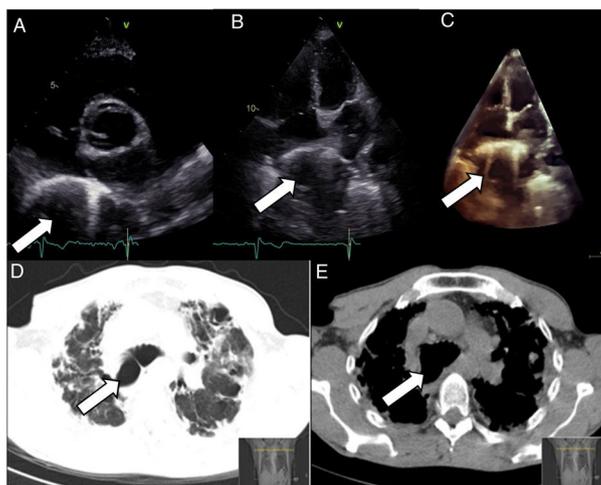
Transthoracic echocardiogram: parasternal short-axis view (A); two-dimensional apical 4-chamber view (B) and three-dimensional 4-chamber view (C) revealing a very large circular retroatrial mass, with irregular hyperechoic borders and hypoechoic center (arrow); thoracic high-resolution computed tomography, axial planes (D and E), revealing tracheobronchomegaly (arrow).
